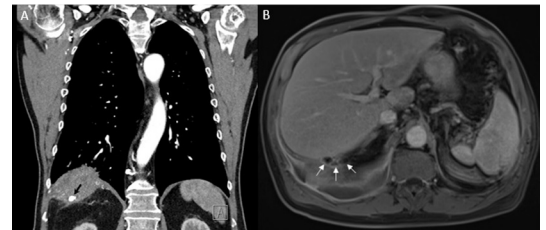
(A) Coronal contrast-enhanced CT image (mediastinal window) showing an infradiaphragmatic calcification (black arrow) adjacent to the lung mass. (B) Axial, gadolinium-enhanced T1-weighted fat-saturated volumetric interpolated breath-hold examination image showing multiple calcifications (white arrows) posterior to the liver.
